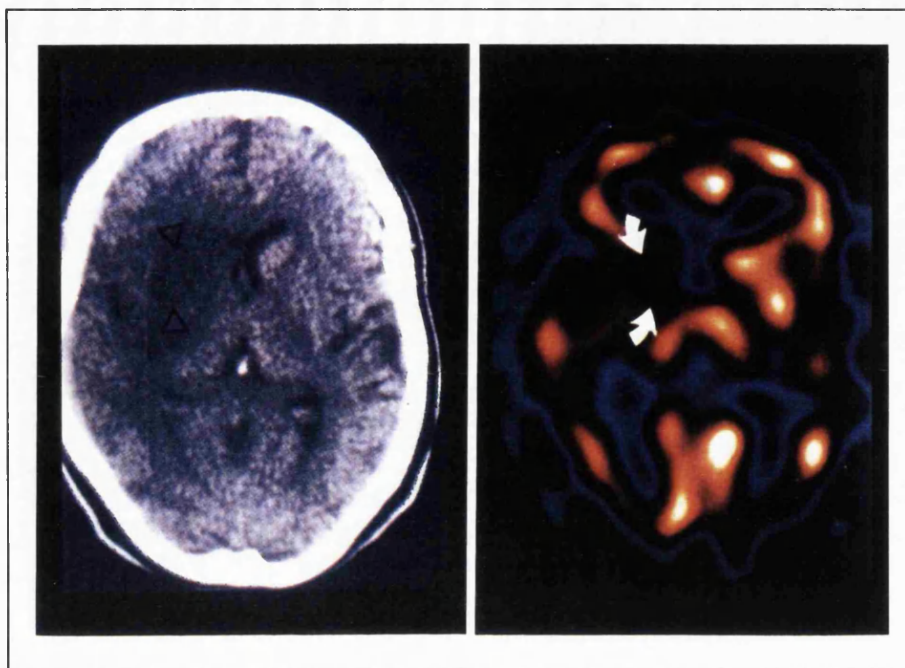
X-ray CT scan and Tc-99m HMPAO SPET images in a patient with cerebral infarction of the right internal capsule involving the ipsilateral thalamus and head of the caudate nucleus and particularly the complex putamen / globus pallidus.
